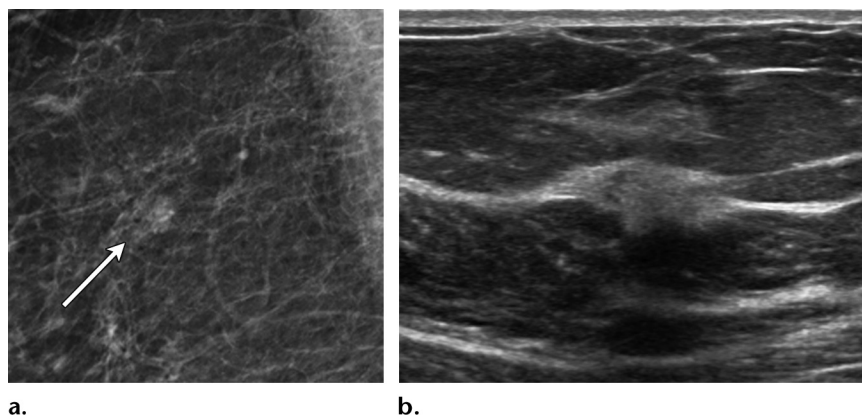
Suspected fat necrosis in a 58-year-old woman with a history of trauma. (a) MLO spot compression mammogram of the right breast shows a focal asymmetry (arrow). (b) Ultrasonographic (US) correlate image shows an echogenic parallel mass with irregular margins. Fat necrosis was suspected, and the lesion was classified as BI-RADS category 3. Follow-up mammography and US performed 6 months later showed no interval involution or improvement. The lesion was upgraded to BI-RADS category 4b. Biopsy revealed grade I invasive ductal carcinoma (IDC) and invasive lobular carcinoma. Fat necrosis should evolve to a more typical benign appearance over time (ie, increased fat and dystrophic calcification with decreased soft-tissue imaging characteristics).
